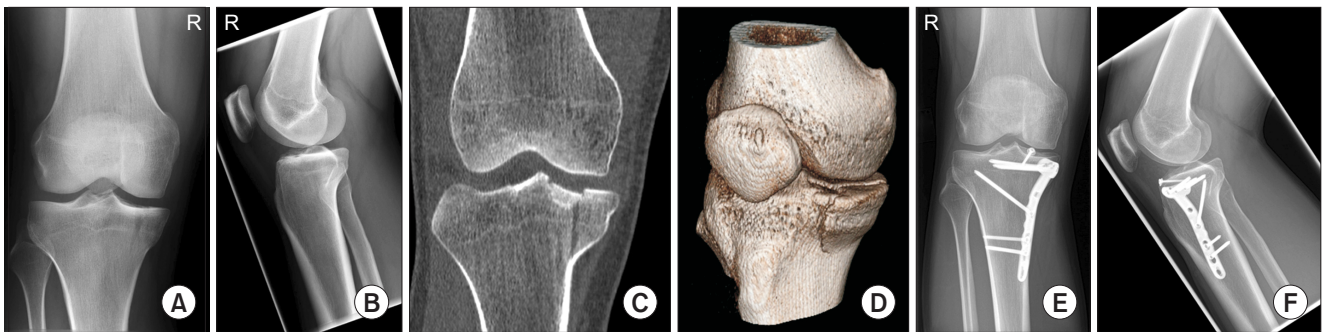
(A-D) Clinical case of a 27-year-old male patient who drove an e-scooter to work and fell off the vehicle after he struck a bump on the road. Clinical examination, X-ray, and computed tomography imaging demonstrated a split depression fracture of the medial tibial plateau (41B3.2 according to the AO/OTA classification). Open reduction and internal fixation was performed 2 days later. (E, F) One year after the operation, the patient demonstrated good recovery with no pain at all, as well as a good joint function with a range of motion of 5° extension and 150° flexion.
